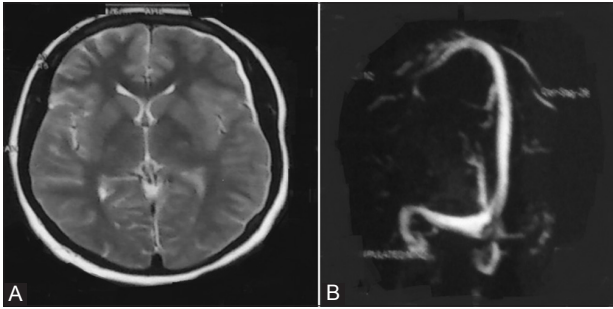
(A) T2 weighted brain MRI revealed high signal intensity at left frontal lobe of subdural hematoma. (B) Brain MR venography shows a filling defect in favor of left transverse sinus thrombosis.
